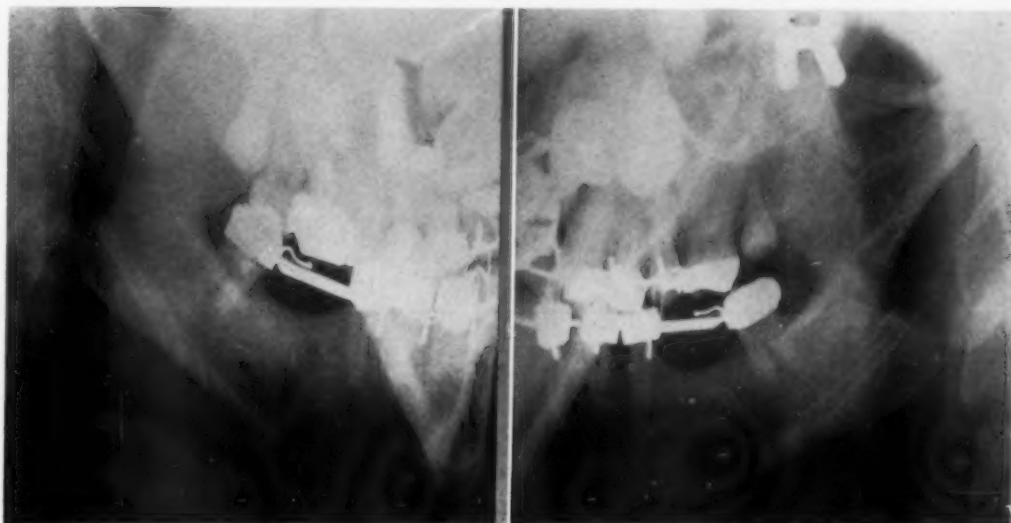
Roentgenograms of mandible one week after sectioning.
